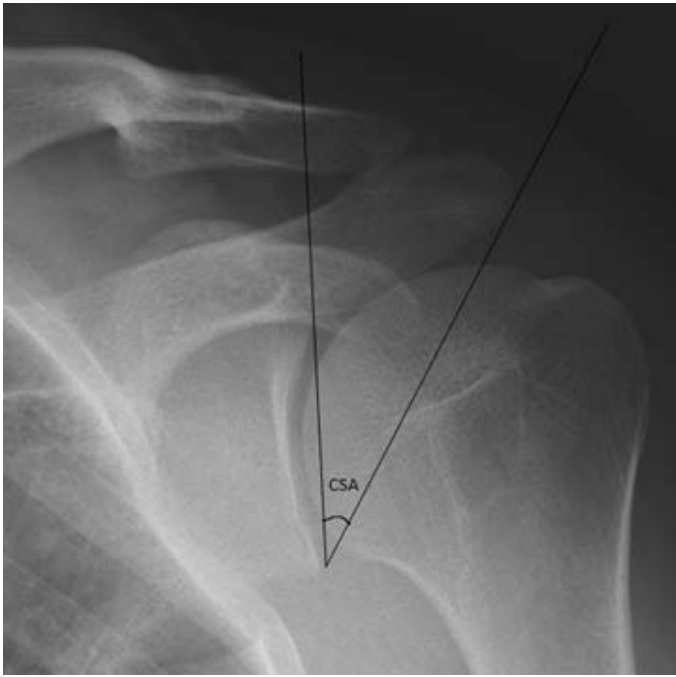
Demonstration of critical shoulder angle (CSA) measurement in a true AP radiograph
